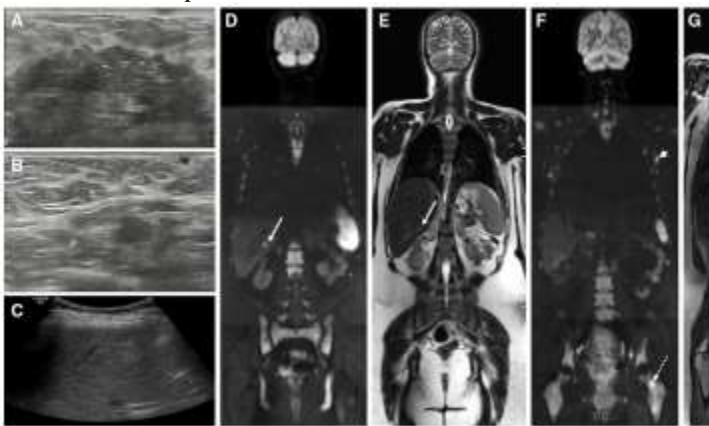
Large left breast tumor (A) and left axilla lymphadenopathy (B) are detected on breast ultrasonography in a pregnant woman with locally advanced breast cancer. at whole-body diffusion-weighted MRI, (D) b1000 diffusion-weighted sequence indicating a bright liver lesion matching the solid lesion at (E) T2-weighted sequence consistent with liver metastasis (arrows). Ultrasound indeterminate screening. In addition, (F) the b1000 diffusion-weighted sequence depicts lymph node metastasis as a bright nodular lesion (arrowheads), and (G) the T1-weighted sequence
